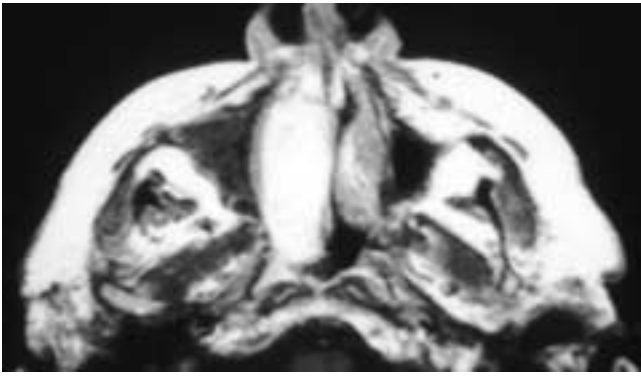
Axial T1-weighted MR image shows a high signal intensity expansile mass in the right nasal cavity. Obstructed inflammatory disease is present in the right antrum. This patient had a hemangiopericytoma.
